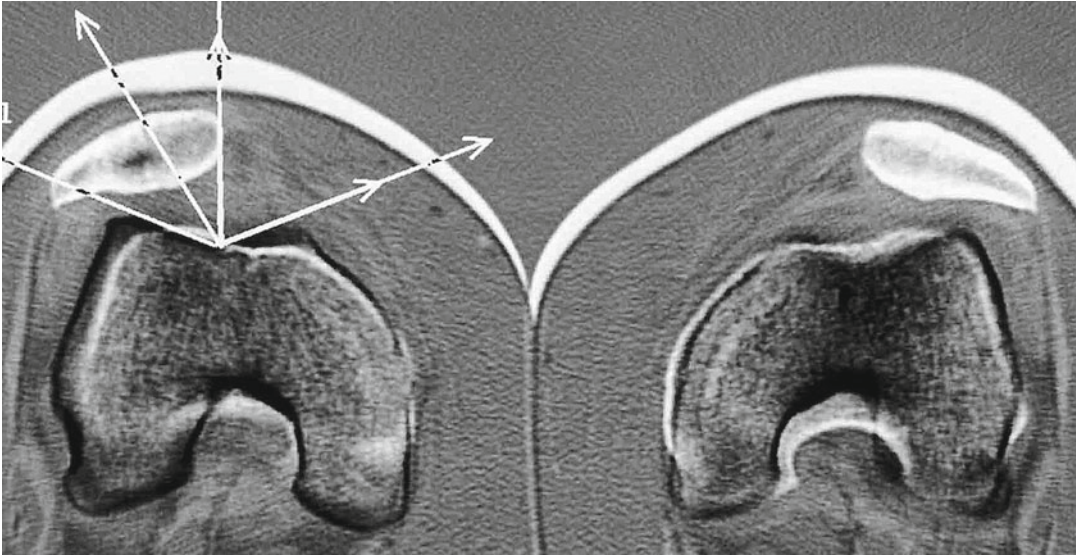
CT at 0° from a patient with anterior knee pain and functional patellofemoral instability in the right knee, however the left knee is completely asymptomatic. In both knees, the PFM is symmetric
